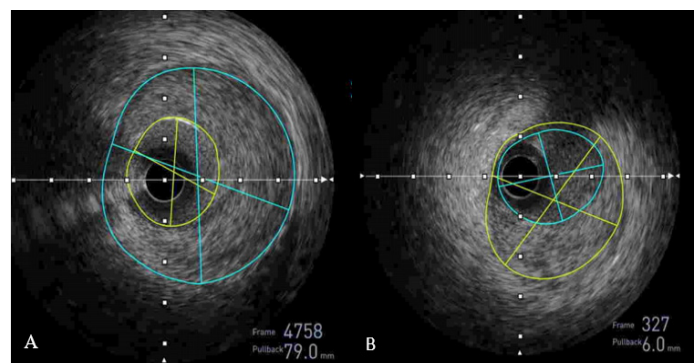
Coronary artery dissections by intravascular ultrasound.
